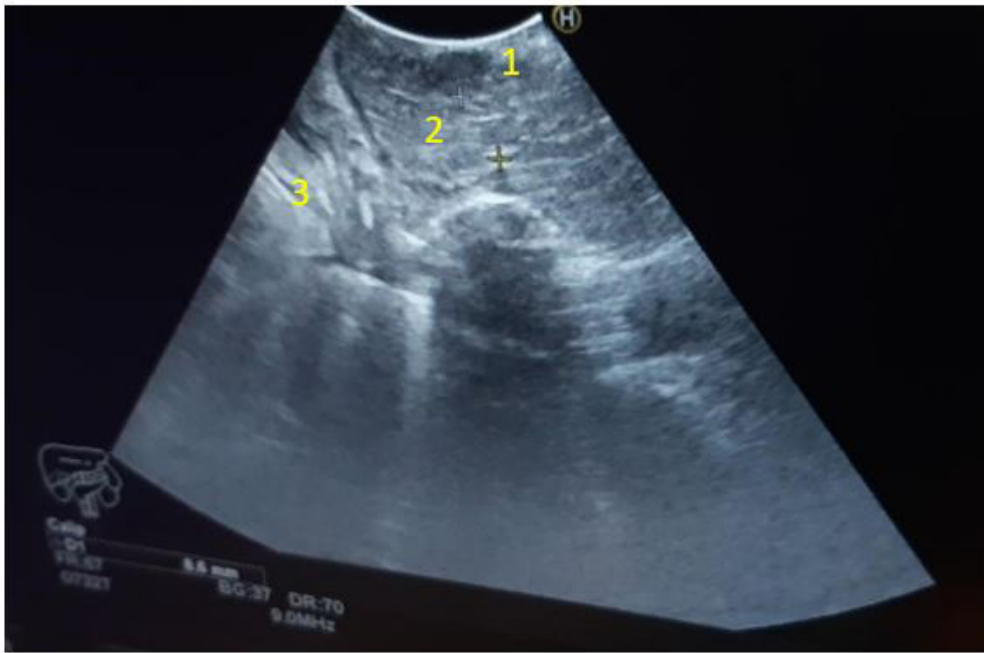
Intraoperative ultrasound: (1) Hypoechoic tumor mass with a maximum axis of 14 mm in the head of the pancreas; (2) Wirsung's canal with endoprosthesis. Note the double rail image; (3) Second duodenal knee
